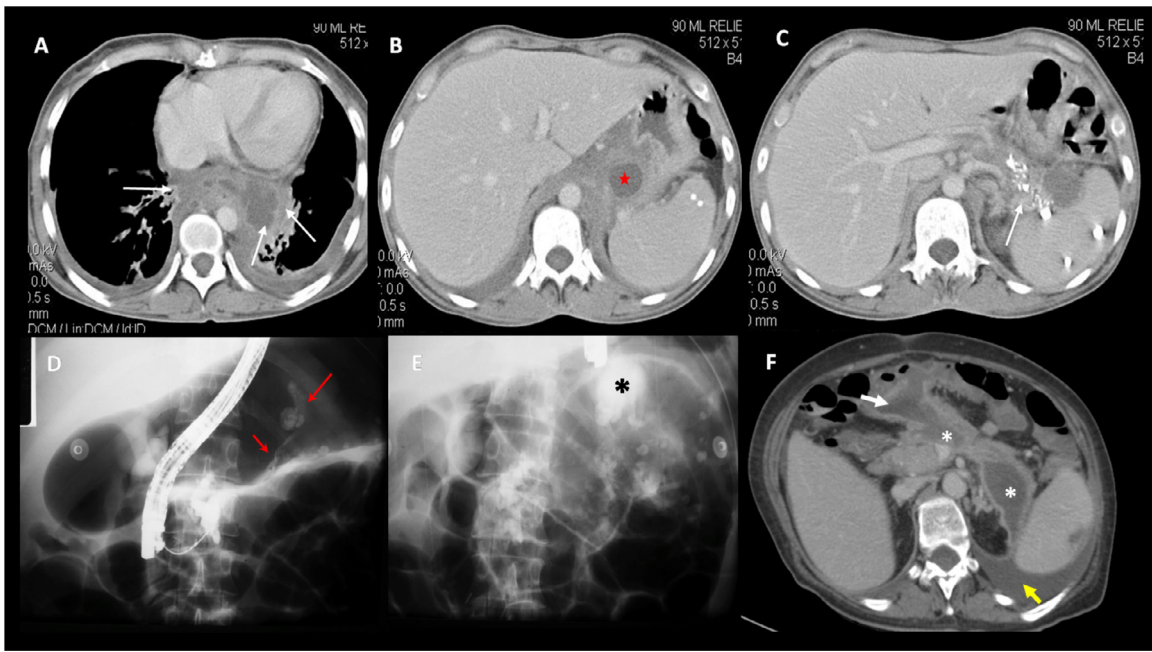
Internal fistula–pleuropancreatic fistula. A 42-year-old female patient with prior history of recurrent acute pancreatitis, last episode 6 months before, complaining of hemoptysis and dyspnea in the emergency room. Chest x-ray and physical examination demonstrated bilateral pleural effusion. The pleural fluid study revealed high levels of amylase, which confirmed the presence of a pleuropancreatic fistula. (A–C) CECT CVP axial images; (*) Pancreatic WON; (Arrows)→Pleuropancreatic communication through a fistulous tract ending in bilateral pleural space through pleurodiaphragmatic tracts. (C) Coarse calcifications in an atrophic pancreas, consistent with chronic pancreatitis complicated with WON and pleuropancreatic fistula that extends to the posterior mediastinum and both pleural spaces. (D, E) Selected images of ERCP depicting the irregular enhance of the Wirsung duct with a fistulous tract that communicates the main pancreatic duct at the body level with WON proven on CT (D); (E) fluoroscopic images during the ERCP at the left pulmonary base depicted a filling cavity (*) that belongs to the posterior mediastinum, consistent with proven pleuropancreatic fistula through pleurodiaphragmatic tract communications. No disconnected pancreatic duct was proven on ERCP. (F) Another patient with extensive peripancreatic collections (WON) that communicate with the transverse colon and the left pleural space through colopancreatic (white arrow) and pleuropancreatic fistula (yellow arrow); (*) WON. (Color version of figure is available online.)
